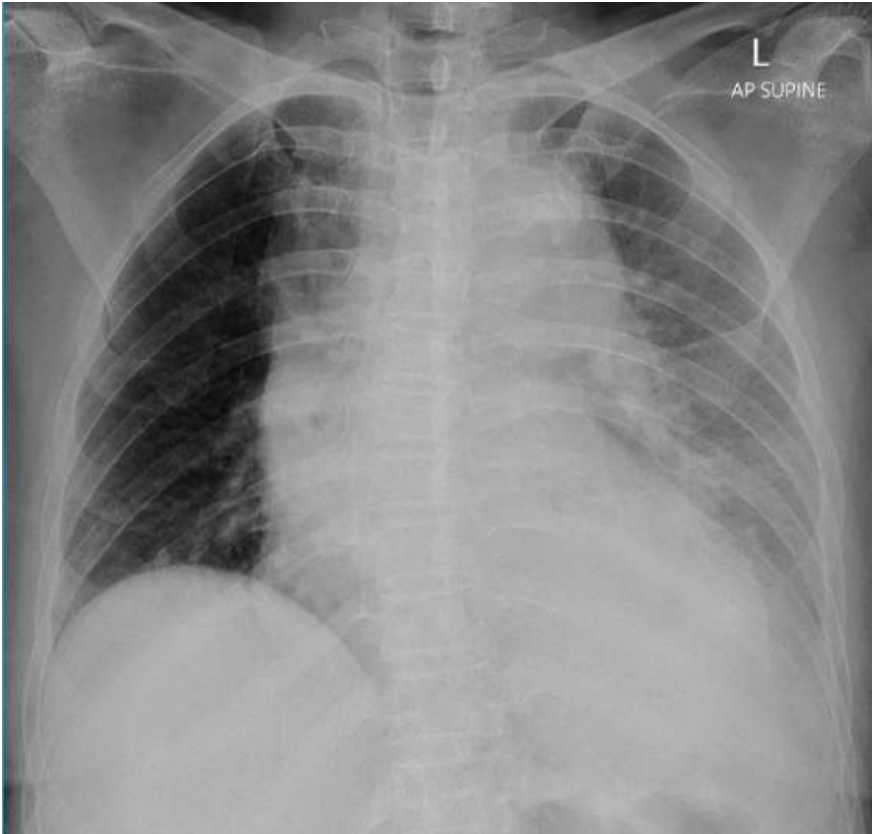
Chest X-ray evaluation revealed a massive left pleural effusion
